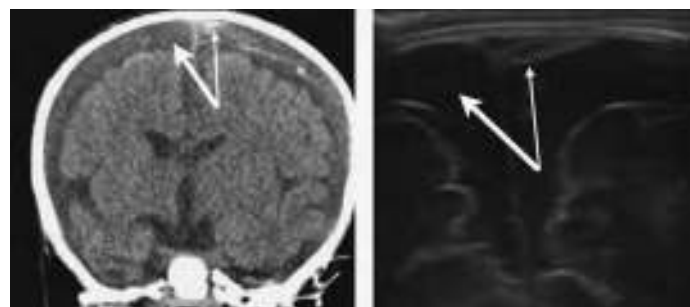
Coronal CT image (left) and corresponding ultrasound image (right) of an acute (thin arrow) on chronic (thick arrow) subdural hemorrhage in a 2-month-old. (Used with permission from reference 13.)
